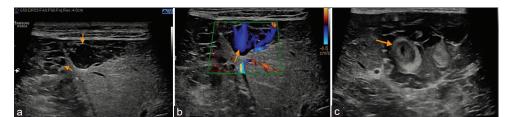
(a) An ultrasound abdomen section obtained with a linear probe demonstrates one of the lesions showing dilated cystic space (orange arrow) with echogenic content in the dependant part (orange arrow); (b) An ultrasound abdomen section obtained with a linear probe demonstrates one of the lesions showing dilated cystic space with color flow within (orange arrow); (c) An ultrasound abdomen section obtained with a linear probe demonstrates one of the lesions showing dilated cystic space with color flow within (orange arrow); (c) An ultrasound abdomen section obtained with a linear probe demonstrates one of the lesions showing hemorrhage/thrombus within (orange arrow)
